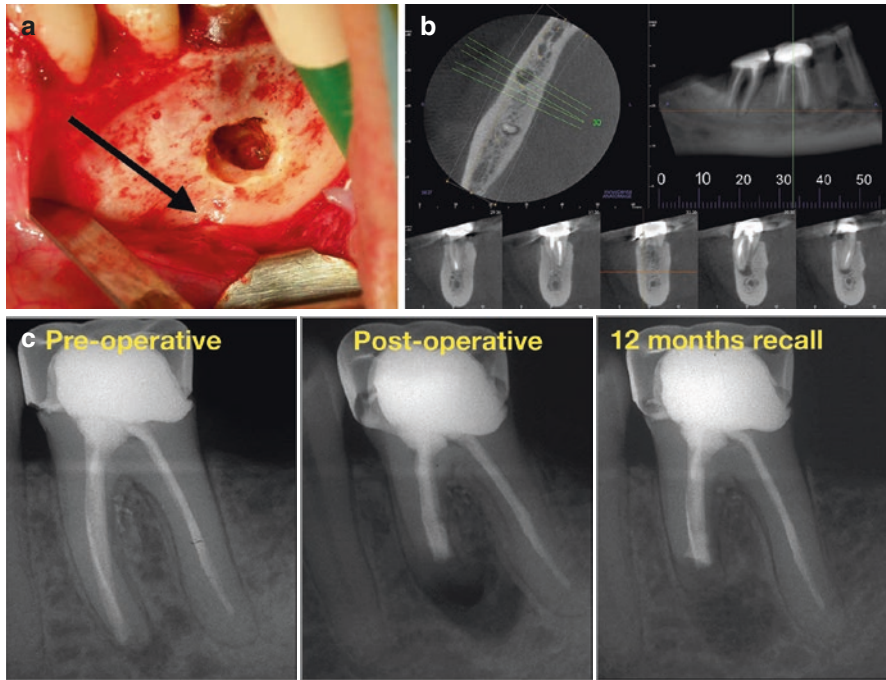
Endodontic microsurgery on mesial root of first mandibular molar. (a) Black arrow showing the position of the mental nerve. Note the thickness of the buccal bone. (b) CBCT showing proximity between mandibular molar and inferior alveolar nerve and mental foramen that may be damaged by reflection of the flap or the vertical incision. (c) Pre-op, post-op and 1-year recall radiographs
